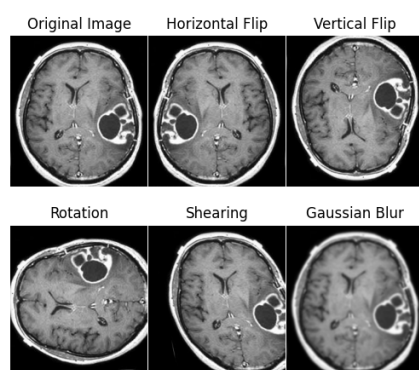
Tools applied to augment the MRI images. Input image sample taken from the BT-3264 dataset [17].
